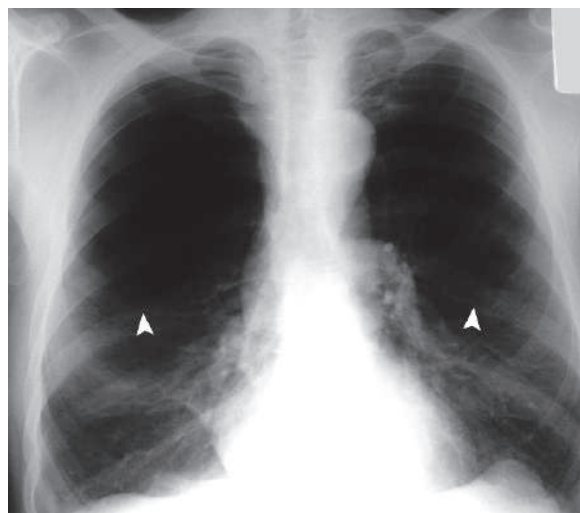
Posteroanterior plain chest radiograph of a patient with vanishing lung syndrome shows bilateral giant upper lobes bullae (*arrowheads*)
